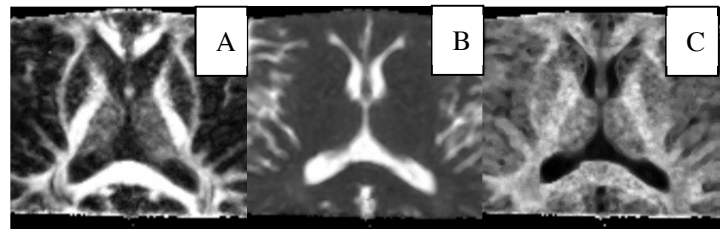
Diffusion metric maps calculated from high resolution DWI data. (A) Fractional anisotropy map, (B) Mean diffusivity map, and (C) Mean kurtosis map.
